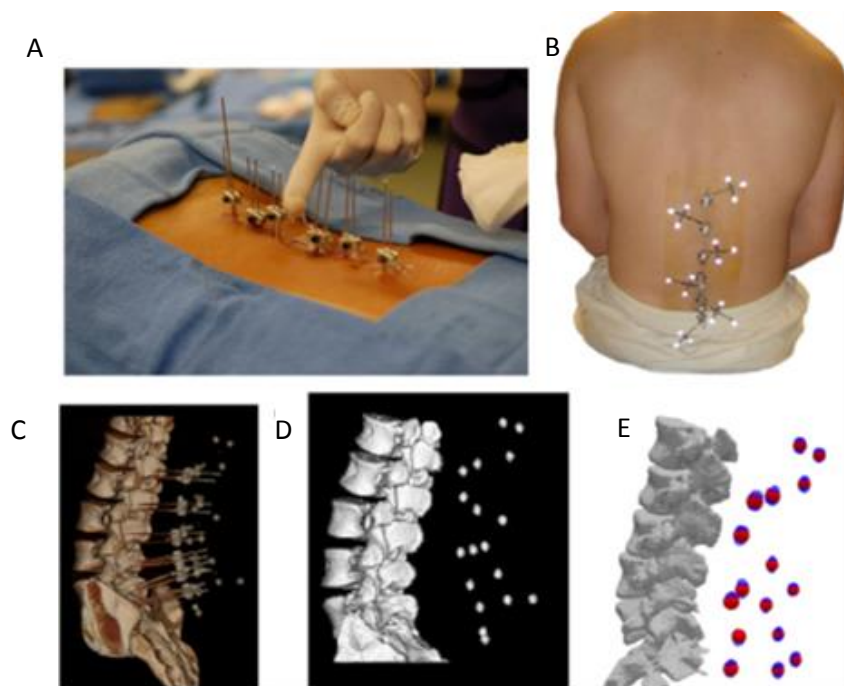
Study protocol; (A) insertion of Kirshner wires in the operating room, (B) attachment of marker triads, (C) full lumbar CT scan, (D) digitization and segmentation of the CT scan, and (E) synchronization of the CT data with the motion capture data (Rozumalski et al., 2008)
